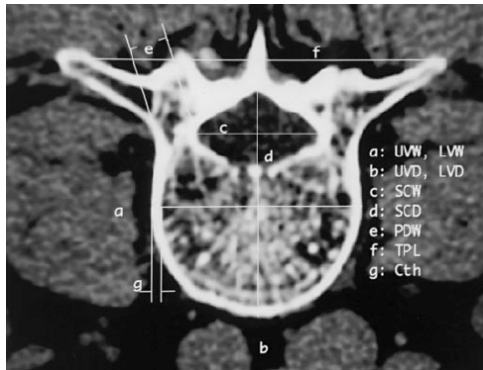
Cross Sectional Vertebral Body Dimension Labels, Zhou, S.H., I.D. McCarthy, A.H. McGregor, R.R.H Coombs, and S.P.F. Hughes. "Geometrical Dimension of the Lower Lumbar Vertebrae-Analysis of Data from Digitised CT Images ." *European Spine Journal. 9.* (2000): 242-248. Print, Used under fair use, 2015.
